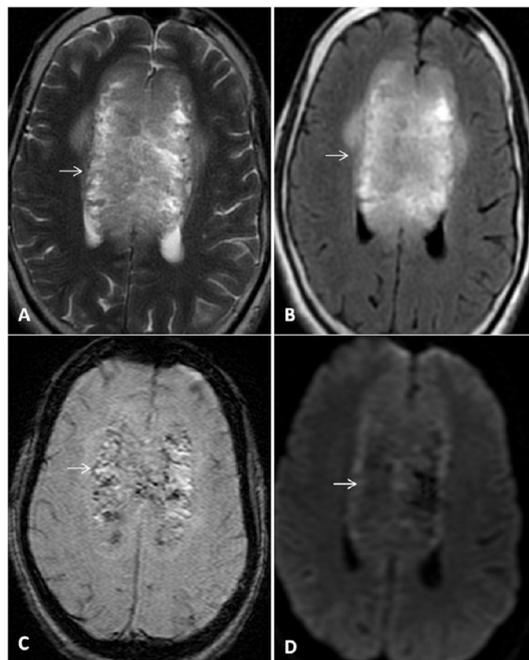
Unenhanced MRI, axial planes through corona radiata. (A) T2-weighted image demonstrates ill-defined heterointense midline lesion involving the corpus callosum (white arrow). (B) Fluid-attenuated inversion recovery image showing heterogeneous hyperintense signals involving the anterior part and body of corpus callosum (white arrow). (C) Gradient echo sequences image depicts multiple foci of blooming within the lesion suggestive of intralesional haemorrhage. (D) Diffusion-weighted imaging shows diffusion restriction predominantly in the periphery of the lesion marking the tumour margins (white arrow).
